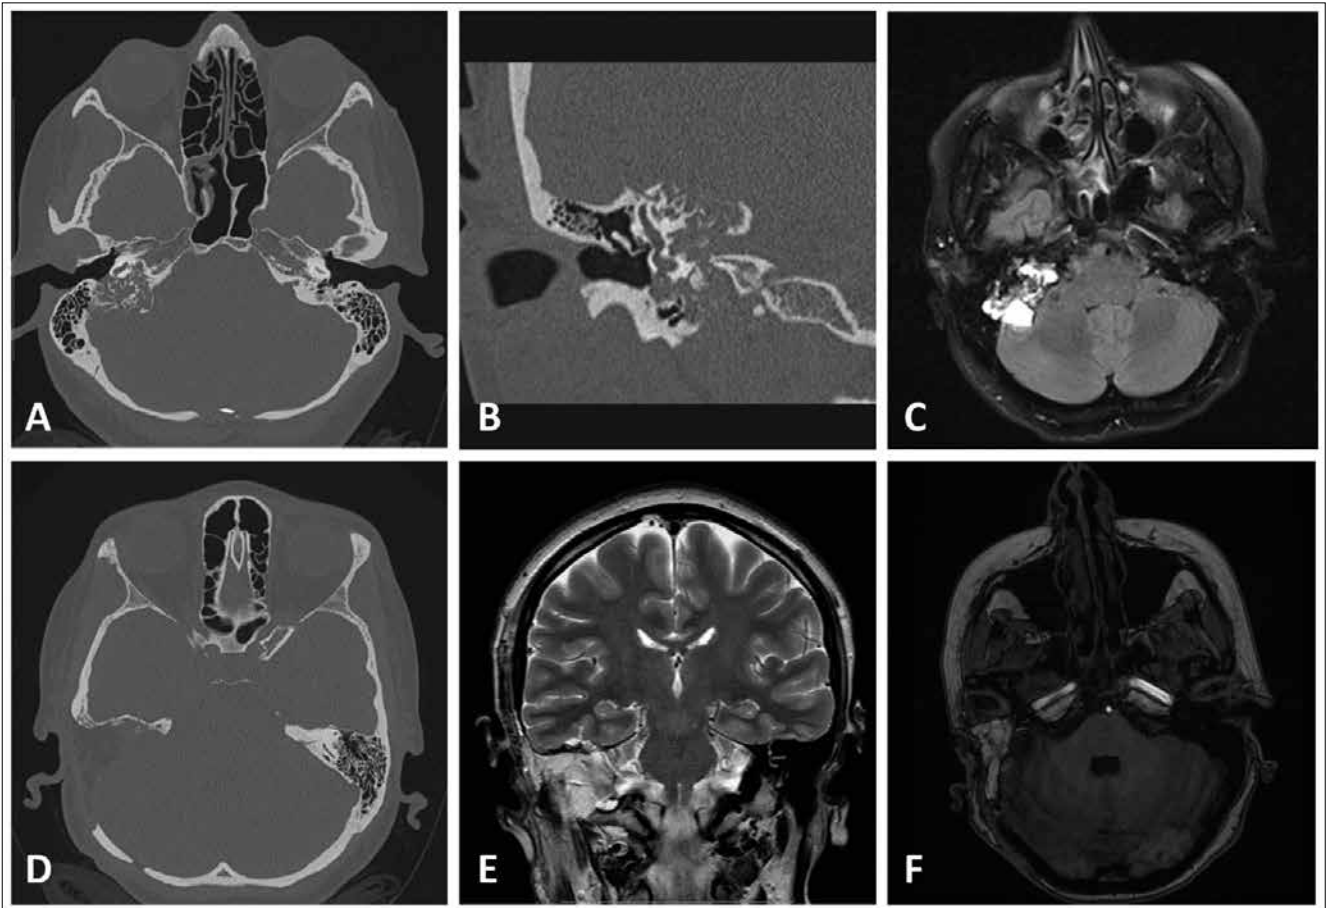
Extended right endolymphatic tumour. A: axial bone CT scan with extended erosion in petrous bone. B: bone erosion and tumour seen in retrolabyrinthine area in a coronal plane. C: axial T2 MRI with flair, showing tumour in the petrous bone and posterior cranial fossa. D: axial bone CT scan after the first surgical step, showing the area of drilled bone of a lateral petrosectomy and the retrosigmoid craniotomy. E: coronal T2 MRI after the first surgical step. F: no residual disease visible on contrast-enhanced T1 MRI after the second surgical step.
